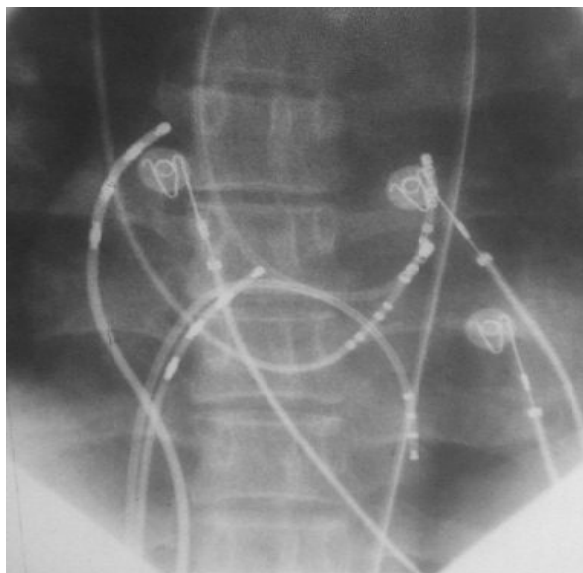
Postero-anterior Xray view of catheters during radiofrequency ablation of an accessory pathway in the left lateral
